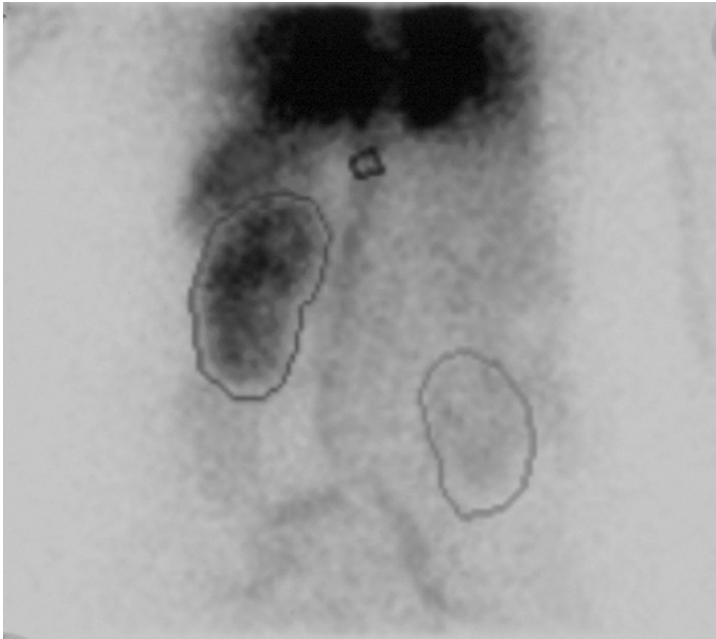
This nuclear scan is from the patient who's IVP is shown in Fig. 8. It is a posterior view; hence the patient's right kidney is seen on the right side of the film. Note the right kidney is much lighter on this film (has far less radiographic uptake) than the left. In fact, measurements showed almost no function from the right kidney and in fact, the kidney had been obstructed for months or years.
